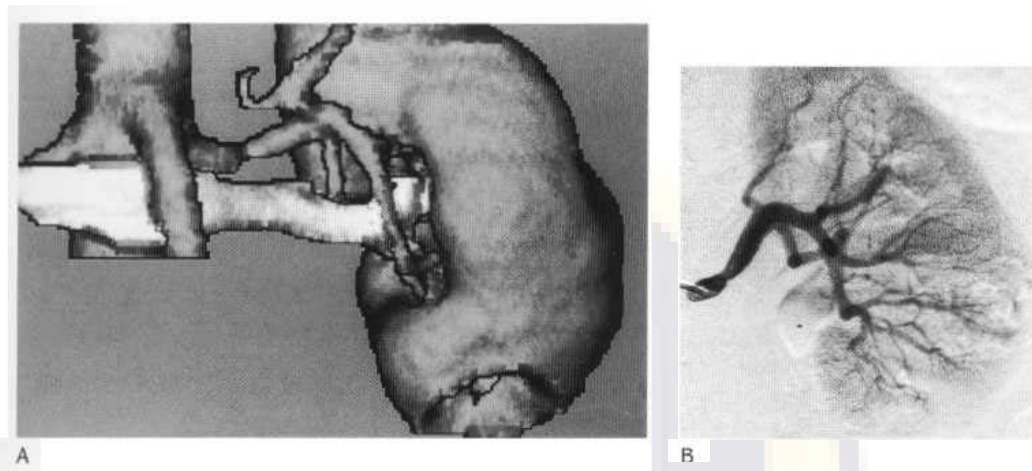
(A) Surface-shaded 3D reconstruction of a spiral CT of the left kidney demonstrating renal morphology and vascular anatomy. The cortical defect seen caudally represented a renal cyst on axial images. Note the mild renal artery stenosis, which was confirmed angiographically (B).
